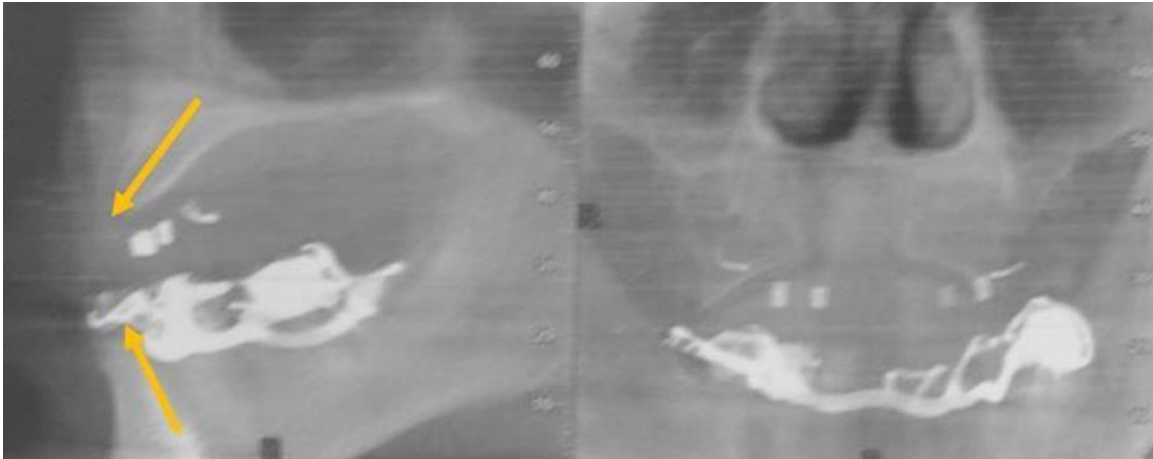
Implant-prosthetic project by cone beam computerized tomography.*
